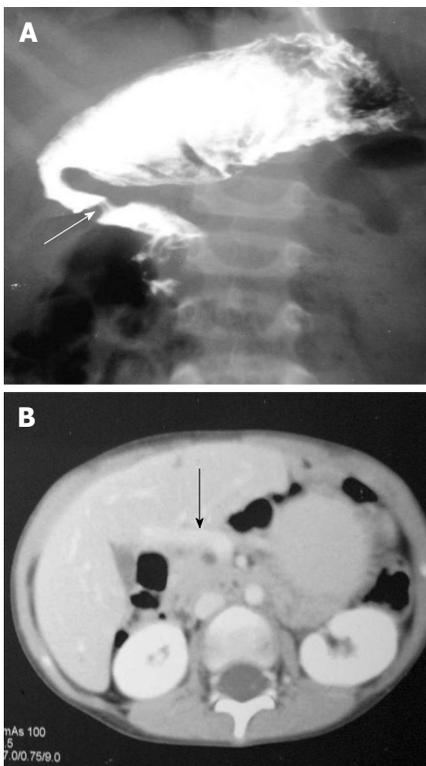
Upper gastrointestinal barium study (A) shows a band like extrinsic narrowing of the first part of the duodenum (arrow), axial computed tomography image (B) reveals the anomalous position of the portal vein anterior to the duodenum (arrow) suggestive of preduodenal portal vein.
